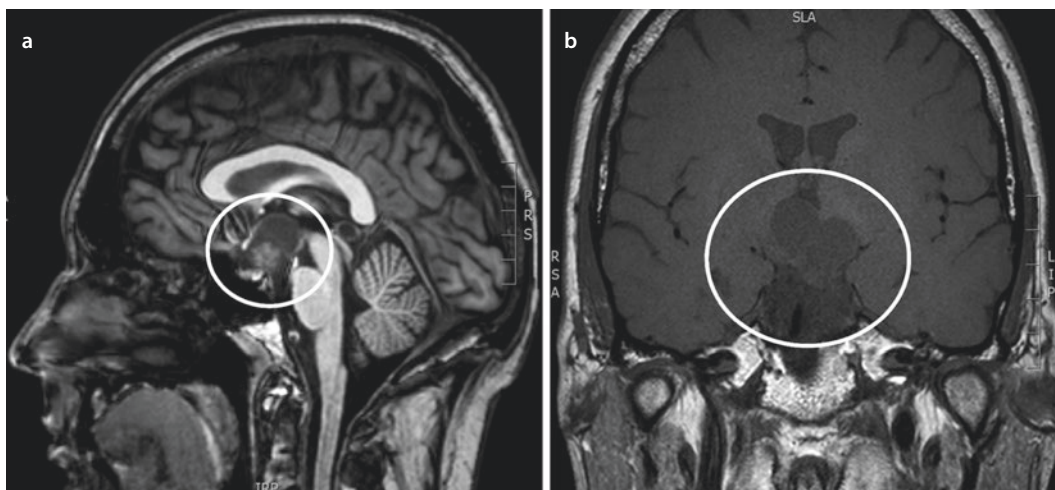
T1-weighted MRI showing the tumor in circle on a sagittal a and coronal b section
